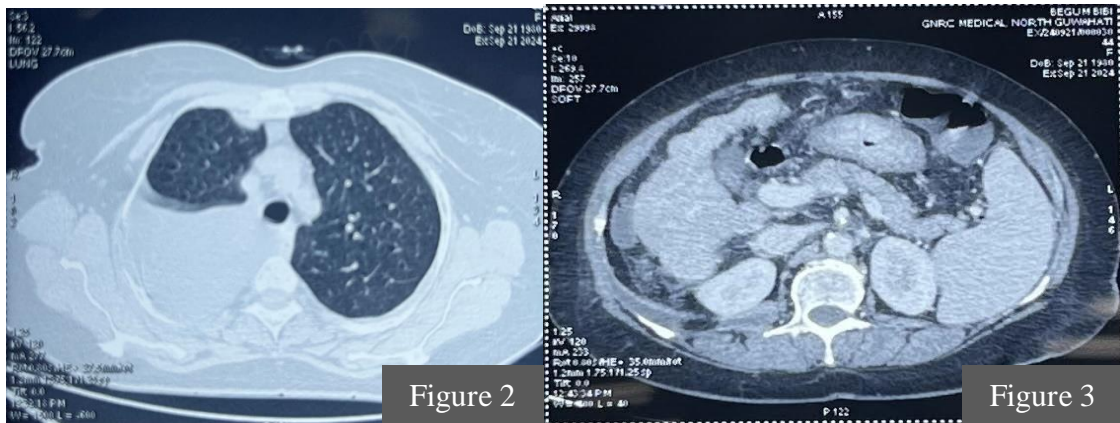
Chest CT shows large right sided pleural effusion with collapse of right lower lung without any significant parenchymal changes and CT abdomen shows shrunken liver with nodular margin, splenomegaly and dilated portal vein indicating chronic hepatic parenchymal disease with features of portal hypertension, however there is no ascites
